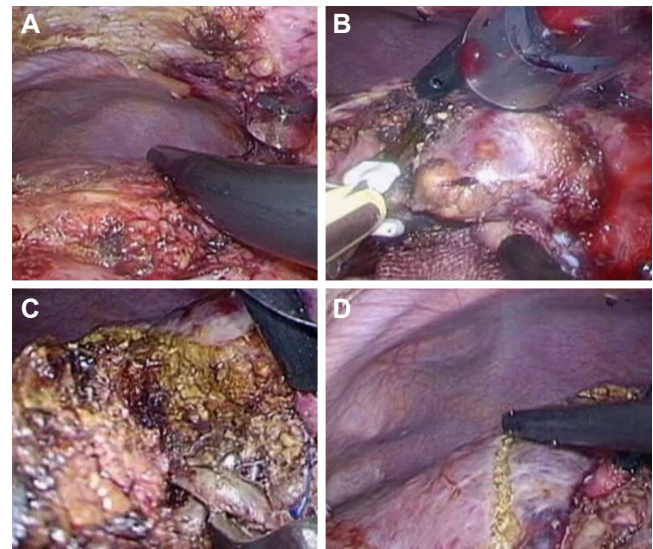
Intraoperative findings. (A): Before the liver transection, minimum adhesiolysis was performed around the area of segment 4 of the liver. Intraoperative ultrasonography was used to demonstrate the locations of the tumors and the line of the umbilical plate, which were marked. (B): The liver parenchymal transection was commenced along a line to the right side of the umbilical plate. (C): During transection along this line, the Glissonian branches to subsegment 4a, and subsequently, 4b, were encircled and divided. (D): After dividing the branches to subsegments 4a and 4b, the area containing the hepatocellular carcinomas was clearly recognized as an ischemic area, prior to resection
